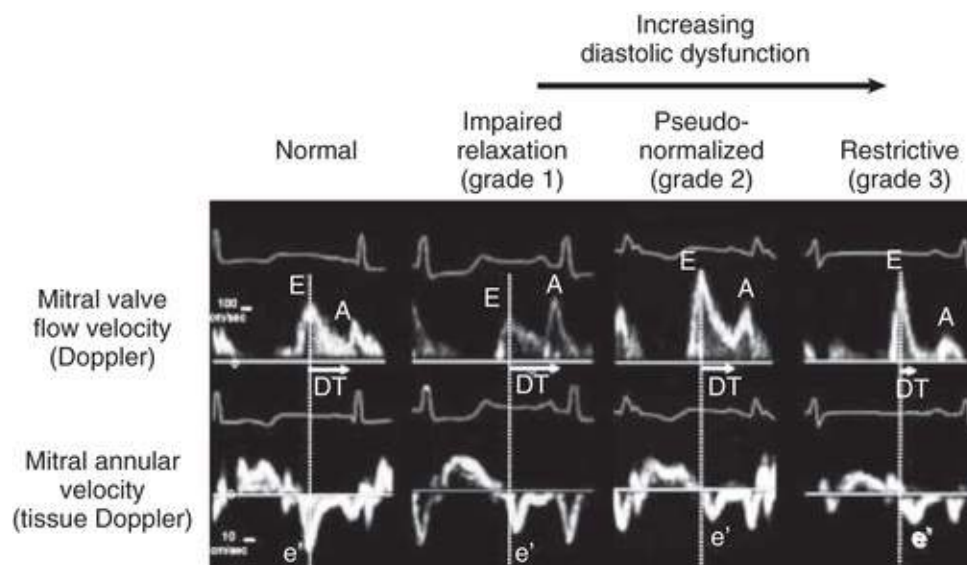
Evaluation of diastolic function based on the left ventricular filling dynamics determined by Doppler measurement of mitral valve flow velocity and tissue Doppler measurement of mitral annular velocity. Normally, the early diastolic mitral flow velocity (*E*) and the mitral annular velocity (*e'*) are brisk and occur almost simultaneously. With mild diastolic dysfunction (impaired relaxation pattern—grade 1) the mitral *E* velocity is reduced and is less than the late diastolic mitral flow velocity (*A*). The *E* deceleration time (*DT*) is increased. With more severe diastolic dysfunction (grades 2 and 3), *E* is increased and the *DT* is reduced. In these patterns, *e'* is reduced and delayed relative to the mitral *E*. (From Little WC, Oh JK. Echocardiographic evaluation of diastolic function can be used to guide clinical care. *Circulation* 2009;120:802.)
